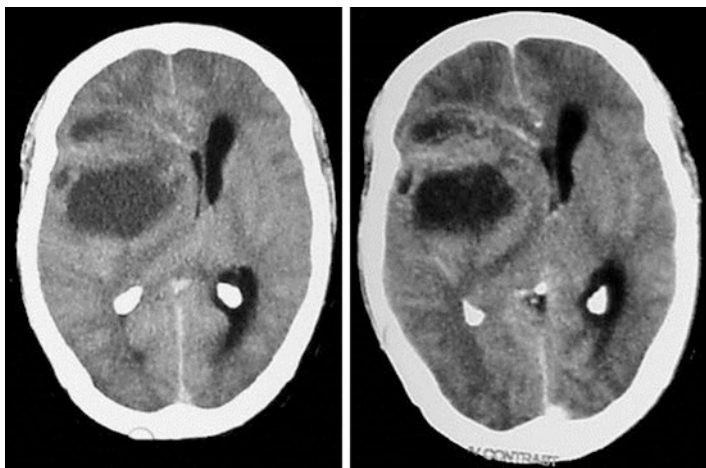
Contrast-enhanced CT brain scan showing a moderately enhancing right frontoparietal glioma coming to the surface. Note it is multicystic with a significant mass effect. The right frontal horn is completely squashed and there is midline shift to the left
